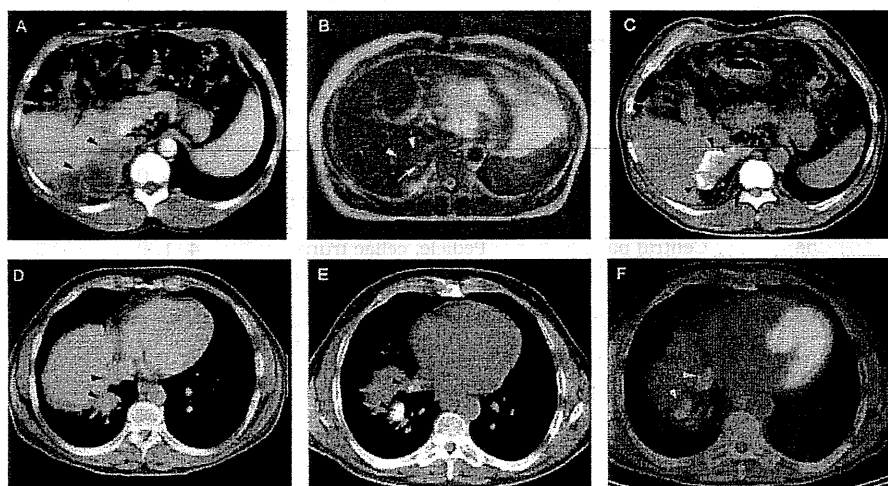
Residual parasitic lesions after LT for AE in (A-C) patient 1 and (D-F) patient 3. (A) Abdominal CT scan: invasion of the liver by diaphragmatic parasitic remnants (arrowheads) 2.5 years after LT. (B) MRI image (T2-weighted) of recurrence in the liver (arrowheads); pathognomonic honeycomb-like vesicles (arrow) 8 years after LT. (C) Abdominal CT scan: calcifications of the recurrent lesions (arrowheads) 22 years after LT. (D) Thoracic CT scan: paradiaphragmatic lung metastases (arrowheads) 7 years after LT. (E) Thoracic CT scan: calcifications of the lung metastases (arrowheads) 20 years after LT. (F) Combined FDG-PET/CT scan (acquired 1 hour after the FDG injection); no FDG uptake by the lung lesions 20 years after LT.
